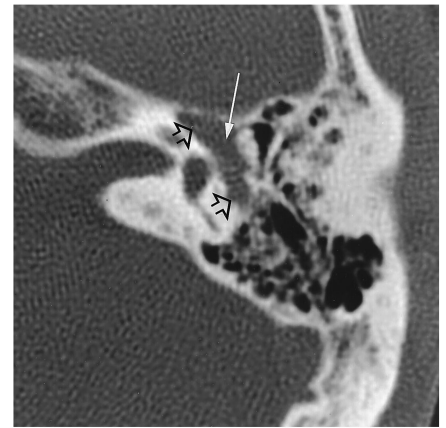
Facial nerve schwannoma: axial CT scan shows smooth enlargement of the tympanic portion of the facial nerve canal (*open arrows*). The tumor invades and fills the anterior epitympanic recess (*long arrow*).
